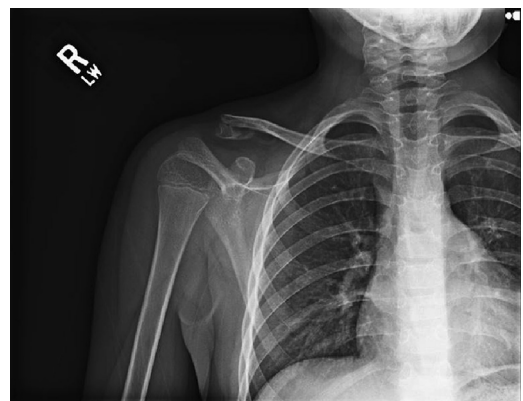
An 11-year-old boy after a fall in gymnastics. Radiographs at presentation show fracture of the distal clavicle with elevation of the proximal fragment.
